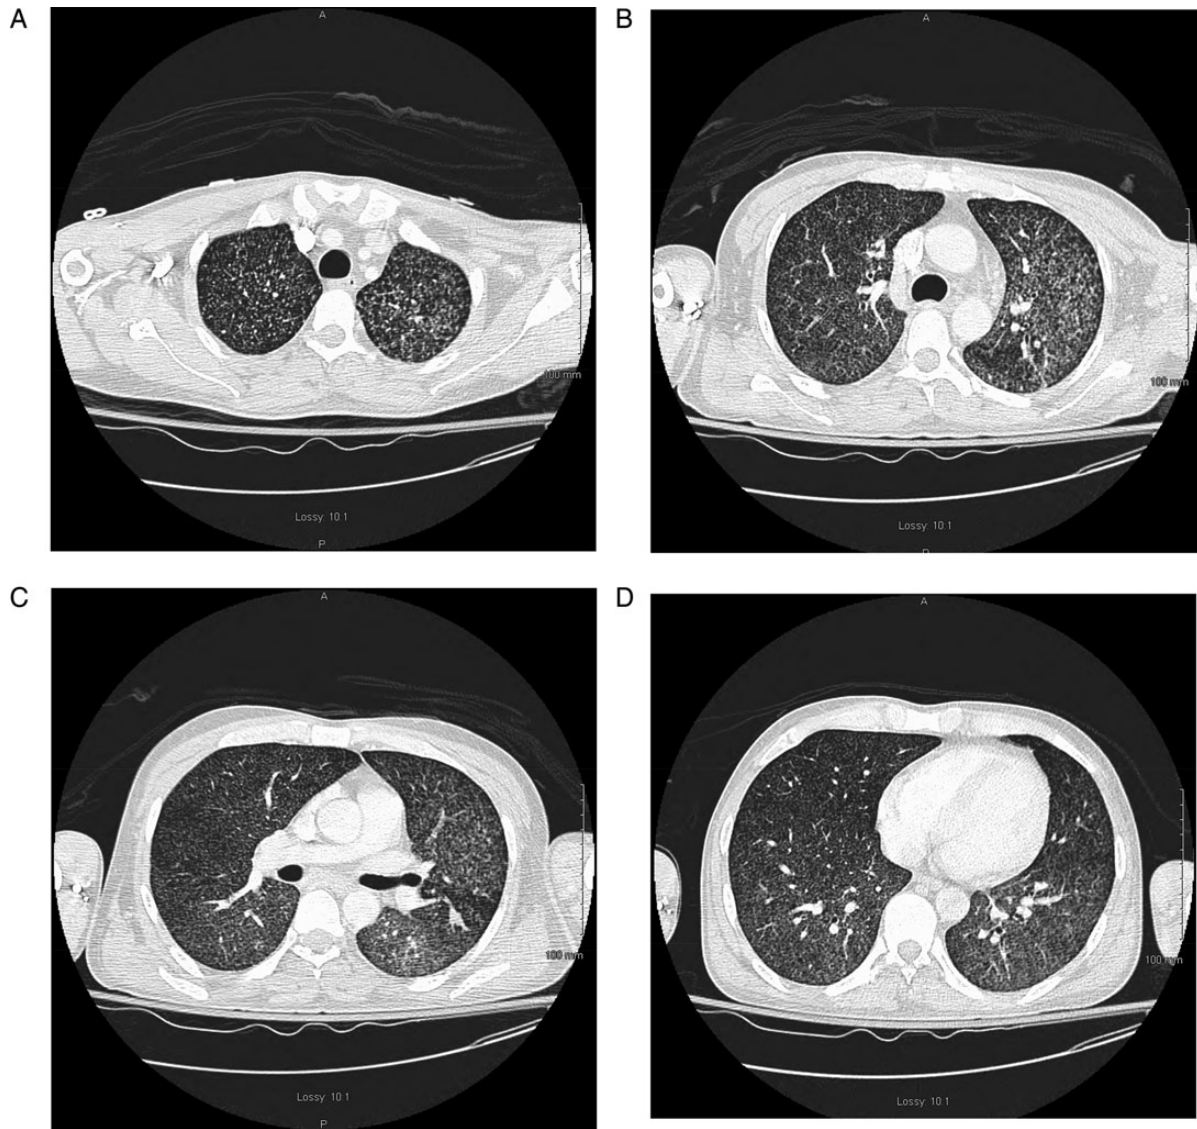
CT with intravenous contrast of the chest at multiple levels showing diffuse micronodular lung disease in random distribution, suggesting hematogenous spread of disease, most commonly seen with miliary TB.
